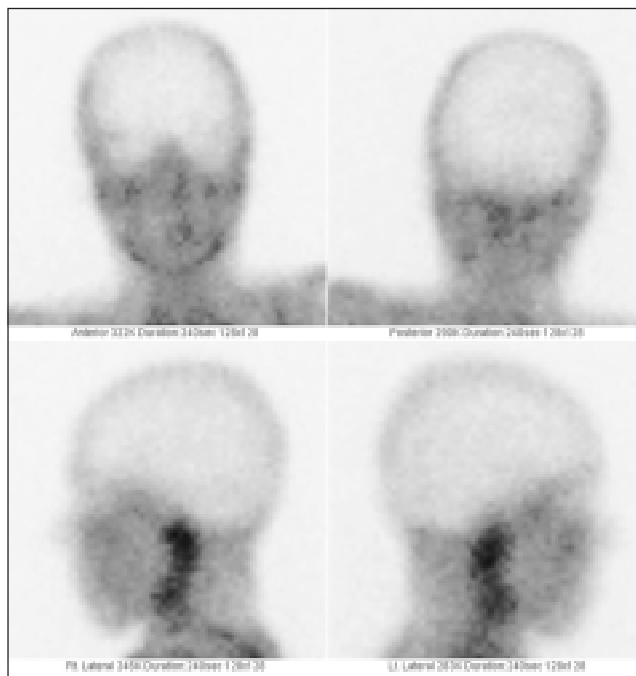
Static brain scintigraphy in the same patient as in Figures 1a and 1b (anterior, posterior and both lateral projections, 4 minutes per frame; anterior and posterior projections are done simultaneously, both lateral projections are also performed simultaneously). No brain perfusion.
